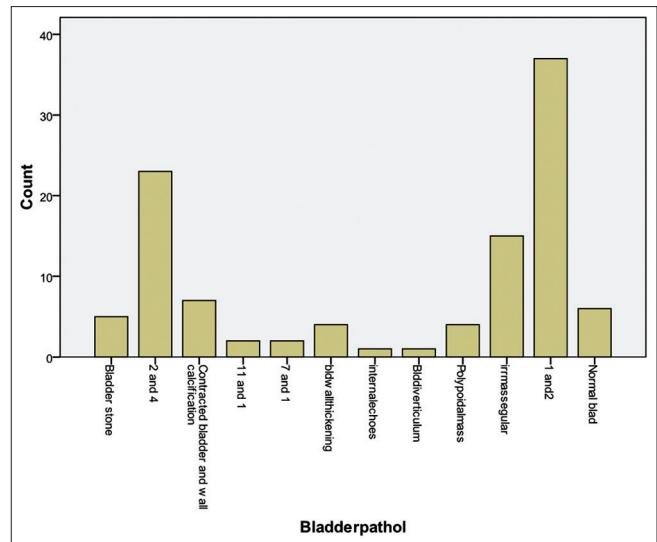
Bar chart is showing a spectrum of urinary bladder pathology following ultrasound. Key: 2 and 4 = Bladder wall thickening and internal echoes, 11 and 1 = Contracted bladder and bladder stone, 7 and 1 = Irregular ladder mass and bladder stone, 1 and 2 = Bladder stone and bladder wall thickening
